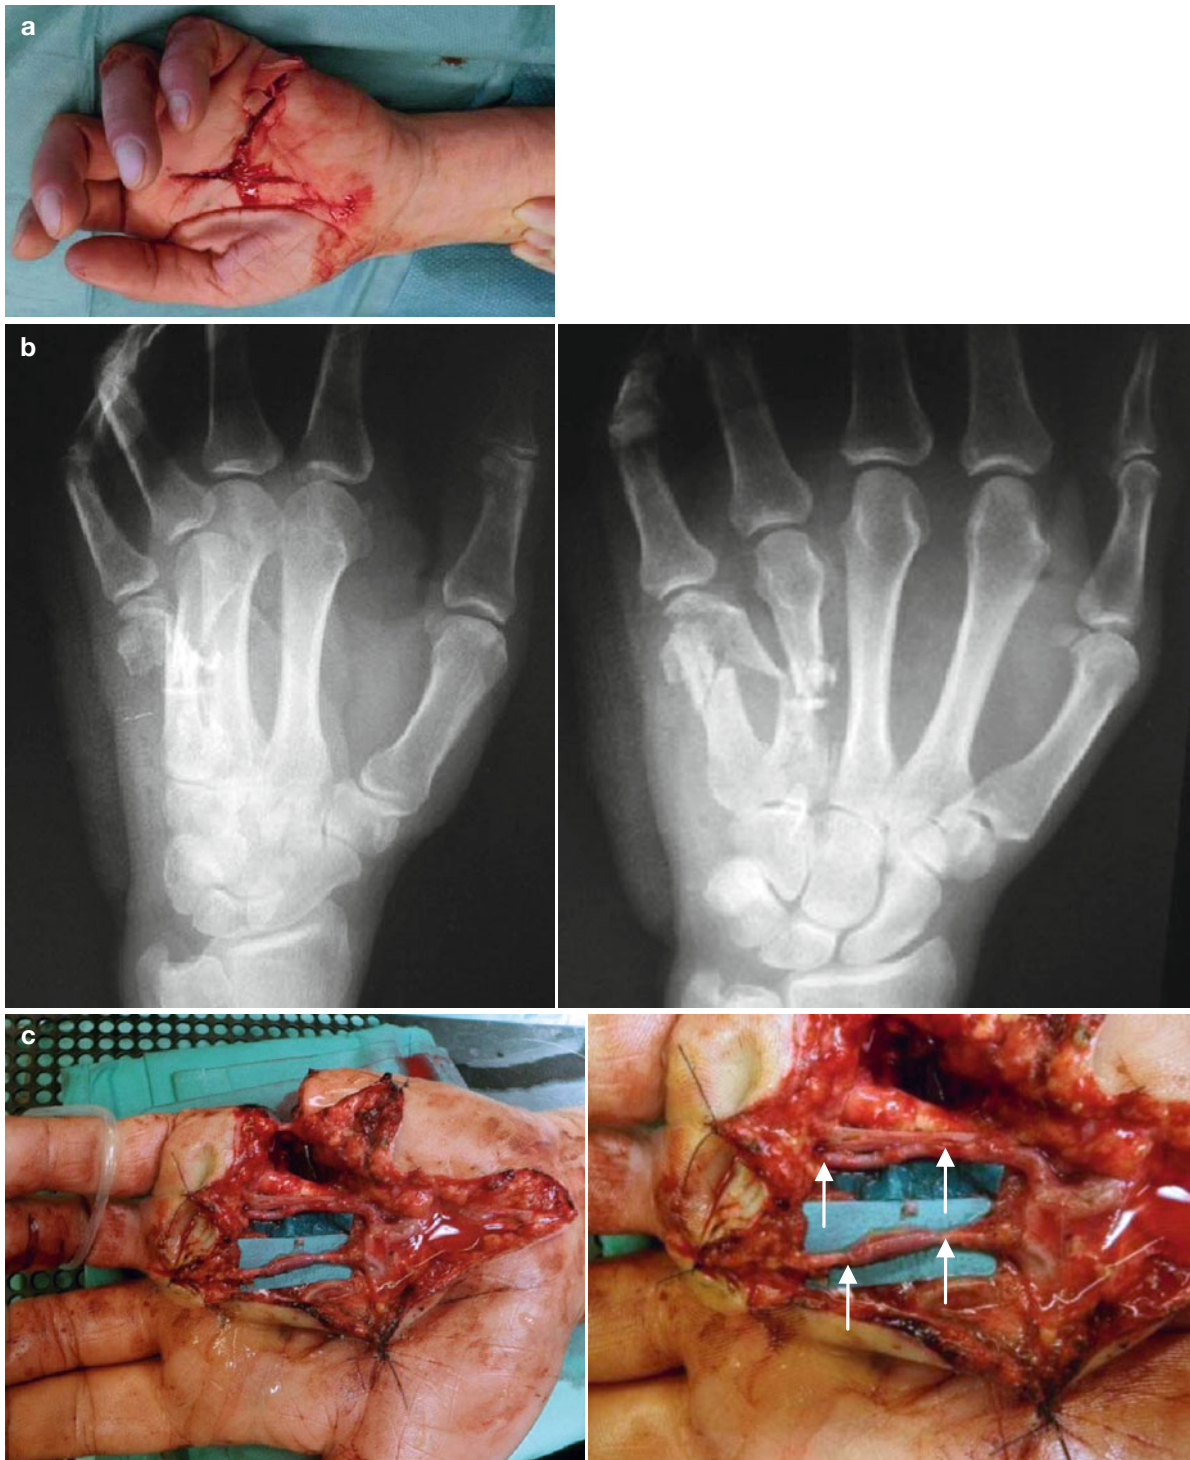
Traumatic partial amputation of ring and small finger (a); radiograph showing severe bone crush of metacarpals (b); revascularization with vein grafts (arrow) (c)
